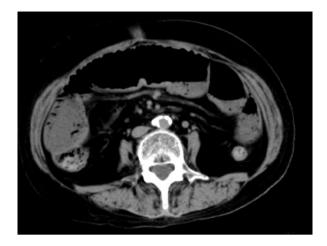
Abdominal computed tomography image showing free air in the abdominal cavity and small cysts within the wall of the bowel
